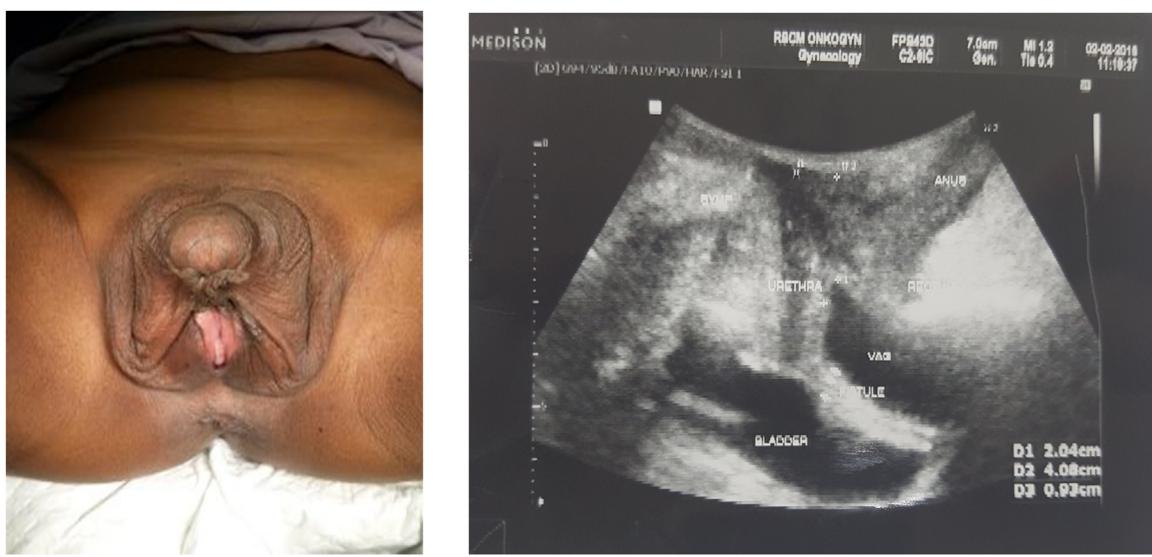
(A) Phenotypic appearance of the patient before surgery (B) Ultrasound of the internal genitalia.
